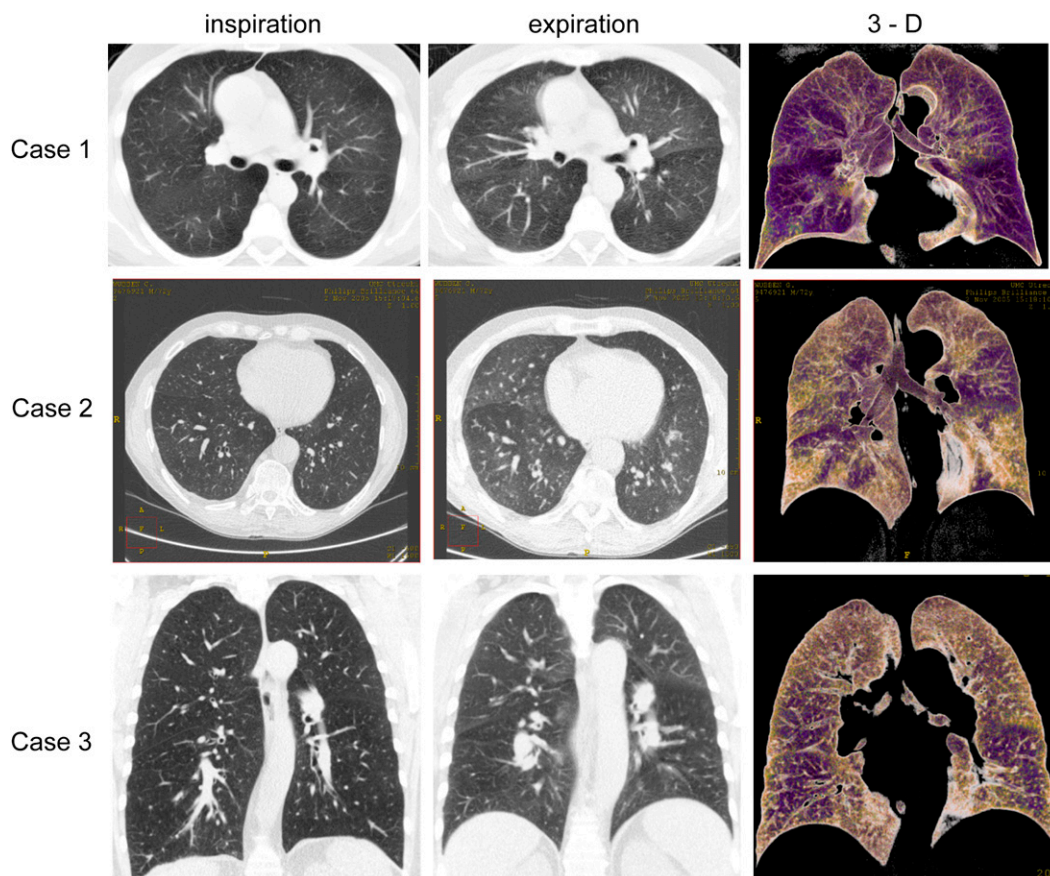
Multislice high-resolution computed tomography scans of the lungs during inspiration (leftmost column) show inhomogeneity of the lung attenuation during inspiration. In Case 1 (top row), a slight mosaic pattern of the lung parenchyma is already present during inspiration. During expiration (middle column), a mosaic pattern is visible in all three cases. Note that areas in which lung density remains virtually unchanged are indicative of substantial air trapping. In expiratory three-dimensional color rendering of coronal 3-cm-thick sections of the lungs (rightmost column) inhomogeneity is even more pronounced with purple areas due to air trapping. Findings are compatible with bronchiolitis obliterans.
